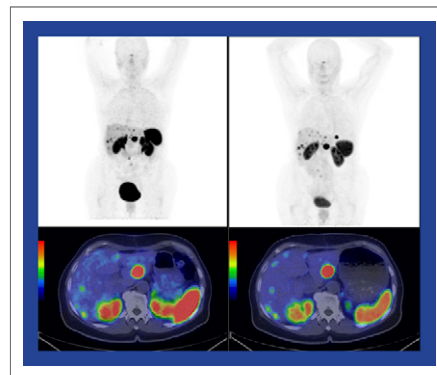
Tumor-to-background uptake ratios with 15 and 50 μg ^{68}Ga -OPS202 on PET/CT. No serious adverse effects were noted with the escalated dose, and some additional lesions were visible.
